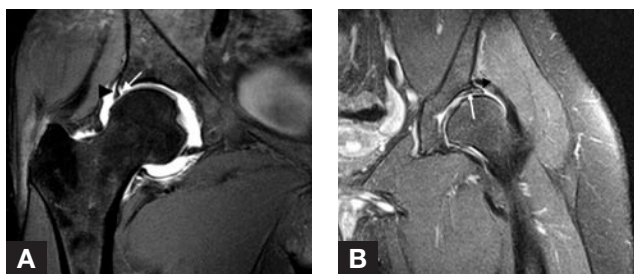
Superior labral tear. (A) Postarthrogram coronal sequence shows labral detachment with fluid separating labrum from acetabulum (solid arrow). There is a normal perilabral recess (arrowhead). The latter is a normal space created by the capsule inserting several millimeters above the acetabular rim. This space may fill with joint fluid or contrast. (B) Coronal proton-density fat-saturated magnetic resonance imaging shows an extensive superior/lateral labral tear with linear increased signal within substance of labrum (solid arrow) and normal perilabral recess (arrowhead).
